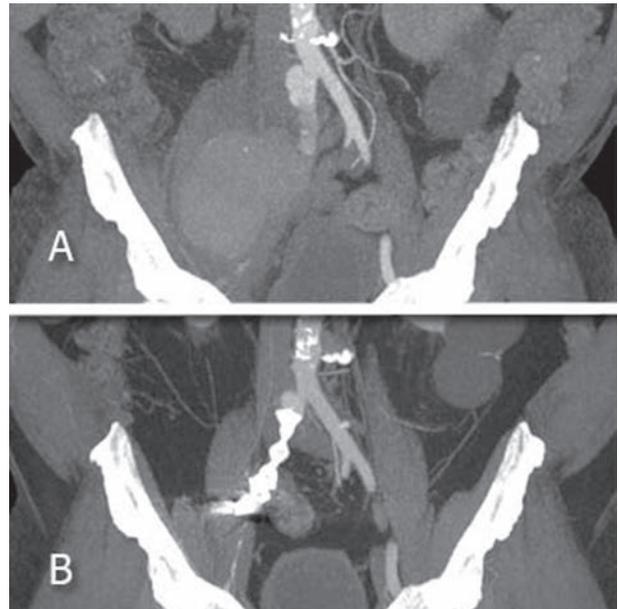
Computed tomography angiography: A-first exam, before the interventional radiological procedure, that shows the pseudoaneurysm. B-control after 10 months, complete resolution of the pseudoaneurysm
